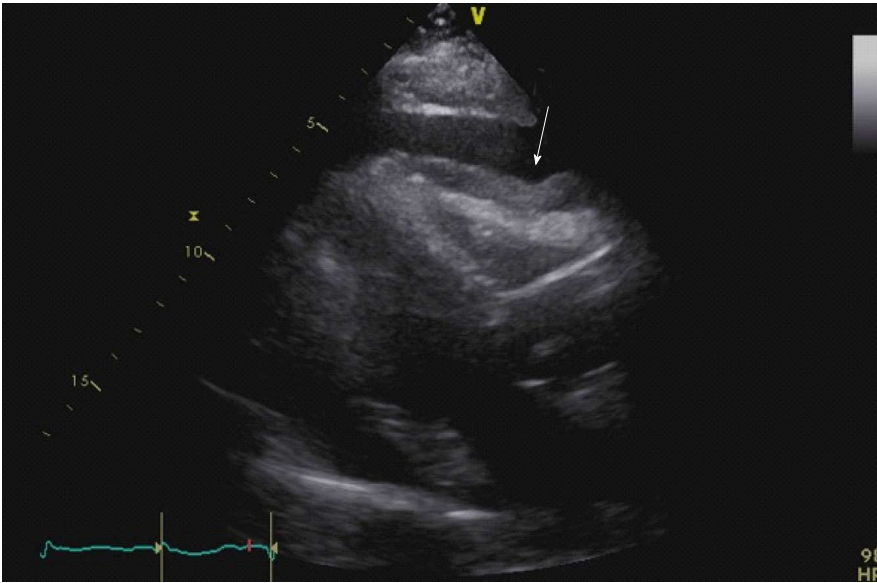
Transthoracic echocardiogram showing a large pericardial effusion with right ventricular diastolic indentation and collapse suggestive of tamponade.
